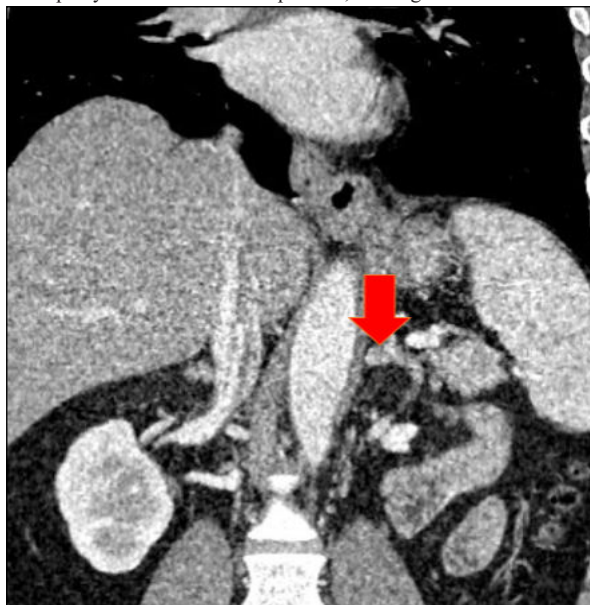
Enhanced Computed Tomography Demonstrating A Left Adrenal Adenoma Showing As An Homogenous Nodule With Minimal Enhancement (Red Arrows).
